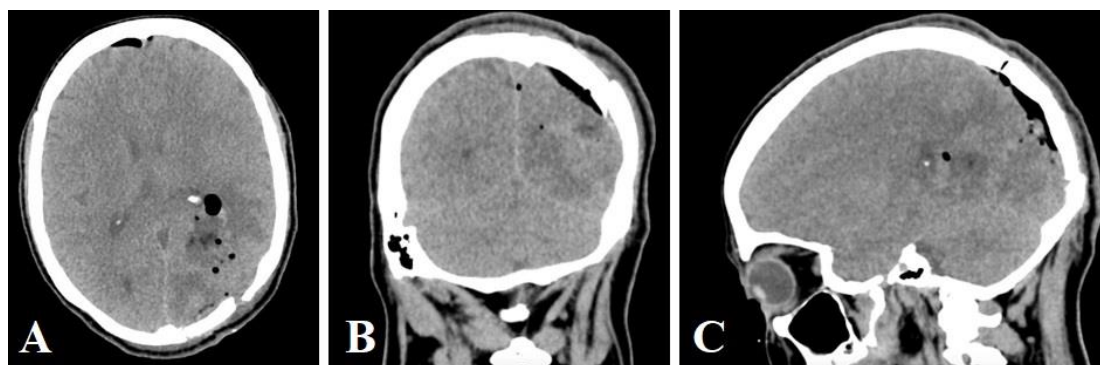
Postoperative axial (A), coronal (B), and sagittal (C) brain CT scan shows no sign of postoperative bleeding or any other acute complications.
